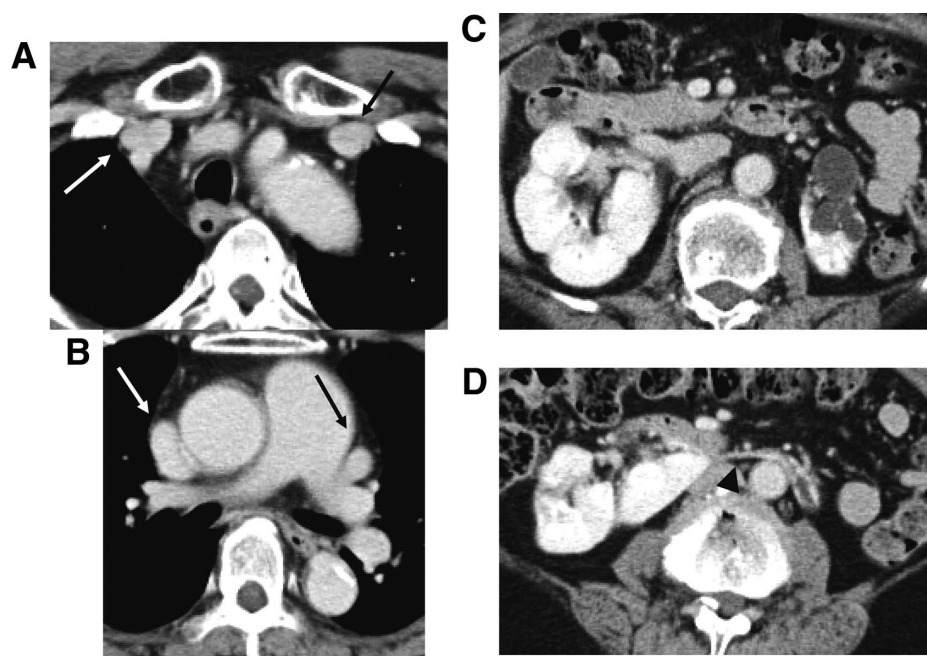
A 68-year-old female with a double superior vena cava (SVC) associated with a horseshoe kidney. (A,B) Chest computed tomography (CT) images with contrast enhancement reveal a right SVC (white arrows) and a left SVC (black arrow) with no bridging brachiocephalic vein. (C,D) Abdominal CT images with contrast enhancement reveal atrophy of the left side of the kidney with multiple cysts, hydronephrosis and a thin line of fusion between the lower poles (arrowhead).
